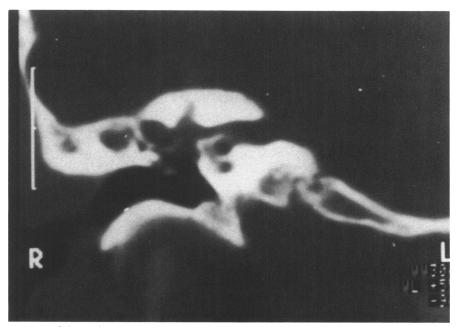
Supralabyrinthine cholesteatoma. CT, coronal section, shows a large osteolytic lesion in the supralabyrinthine compartment of the petrous bone with involvement of the lateral and superior semicircular canals, the geniculate ganglion, and the first portion of the facial nerve.
